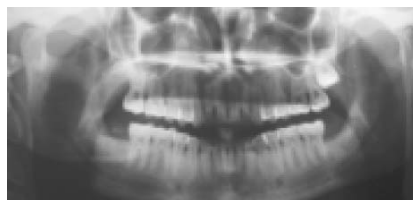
Postoperative radiograph (12 months)
